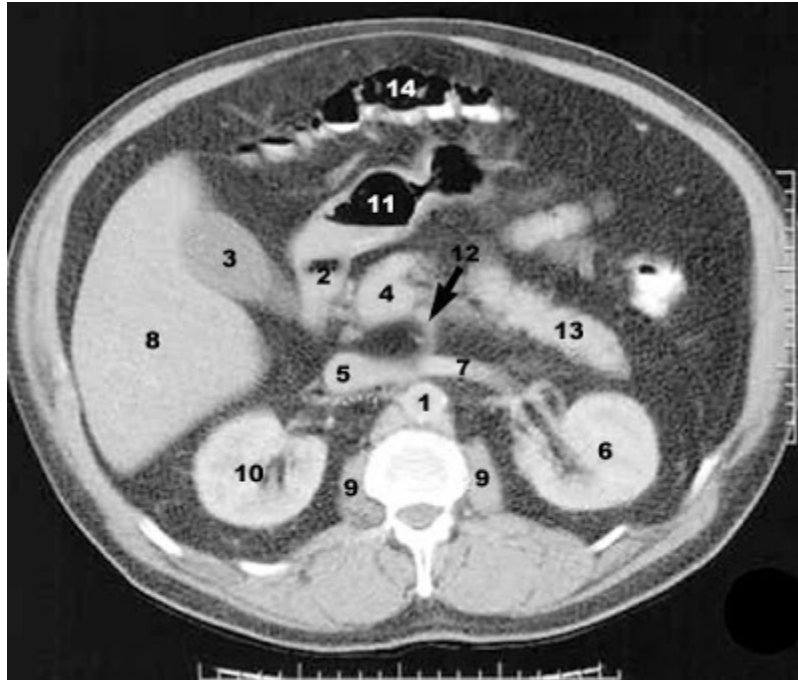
CT scan of the abdomen
